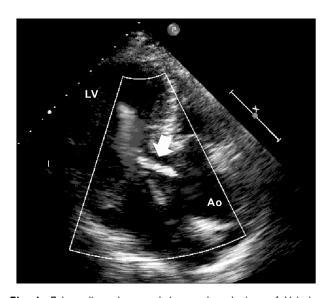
Echocardiography revealed an enlarged sinus of Valsalva with aortic regurgitant jet flow (arrow). LV, left ventricle; Ao, aortic sinus.
